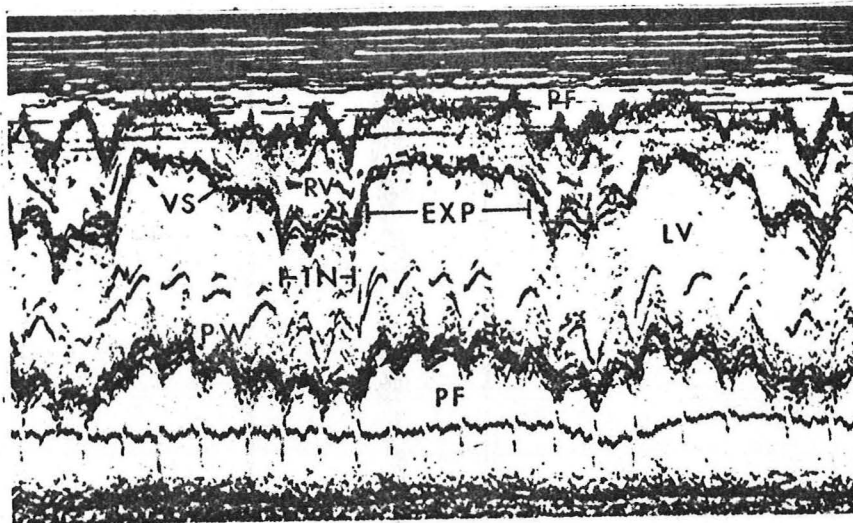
A typical echocardiogram of a patient with cardiac tamponade showing pronounced variations in cardiac dimensions during respiration. IN=inspiration; EXP=expiration; RV=right ventricle; VS=interventricular septum; LV=left ventricle; PW=posterior left ventricular wall; PF=pericardial fluid (65).
